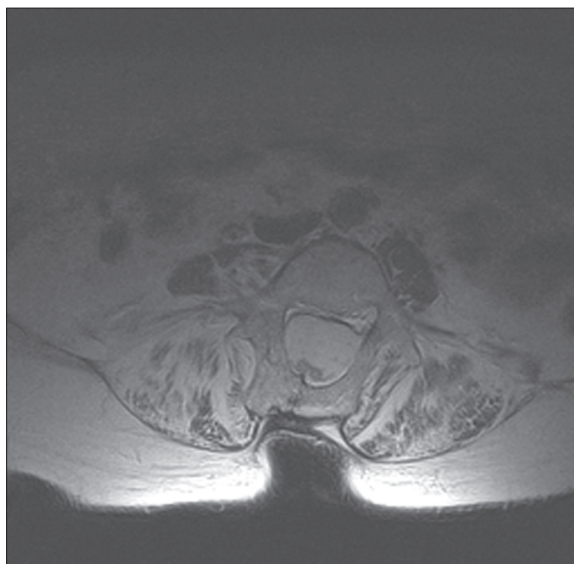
T2-weighted image, axial plane, level L4: a single dural sac containing both hemicords.
